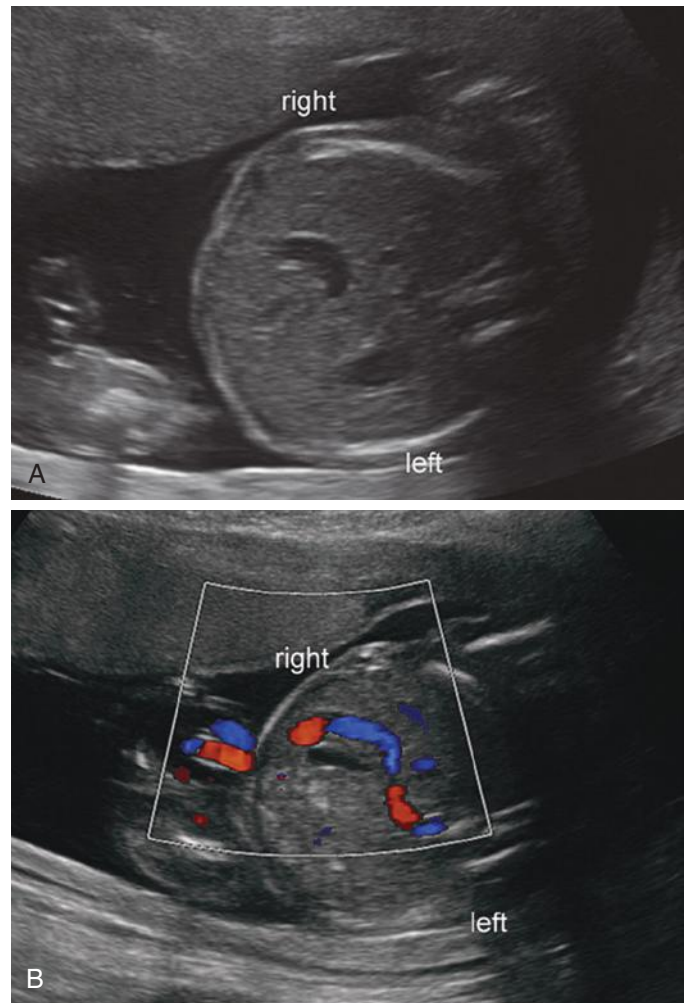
Persistent right umbilical vein. A, In this transverse view of the fetal abdomen at 19 weeks, the J-shaped intrahepatic umbilical vein courses toward (rather than away from) the left side of the fetal stomach. B, Color Doppler sonography reveals the course of the persistent right umbilical vein, located lateral and to the right of the gallbladder.
